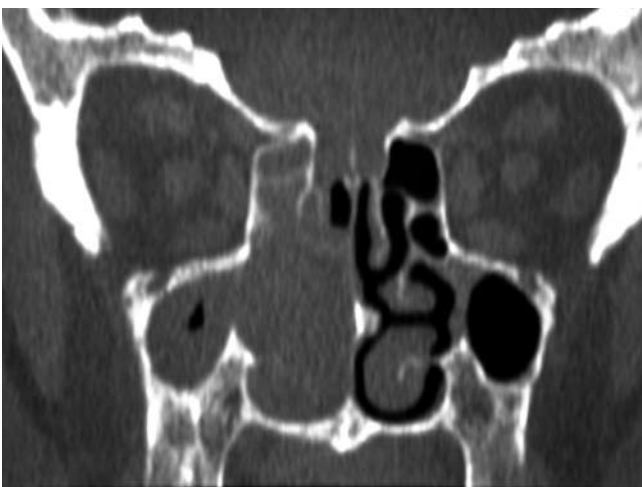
CT shows unilateral growth that occupies right nasal-paranasal sinuses.
